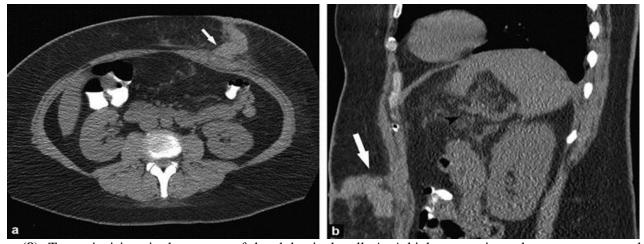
Trocar incision site hematoma of the abdominal wall. A: A high-attenuation subcutaneous accumulation was observed over the trocar incision on an axial CT scan of the upper abdomen (white arrow). B: Upper abdominal subcutaneous hematoma as seen on sagittal CT (white arrow) (20).
